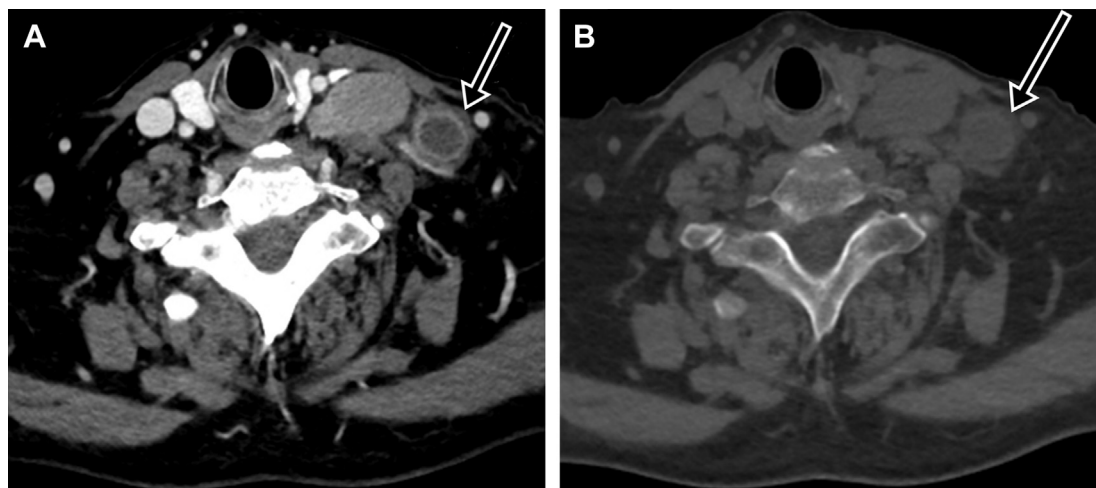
Virtual noncontrast image. (A) Axial contrast-enhanced dual-energy computed tomography image of the neck showing a necrotic left supraclavicular metastatic lymph node (arrow). (B) Virtual noncontrast reconstruction showing subtraction of the enhancement in the cervical vessels and soft tissue. Notice the subtraction of the rim enhancement of the necrotic lymph node (arrow).
